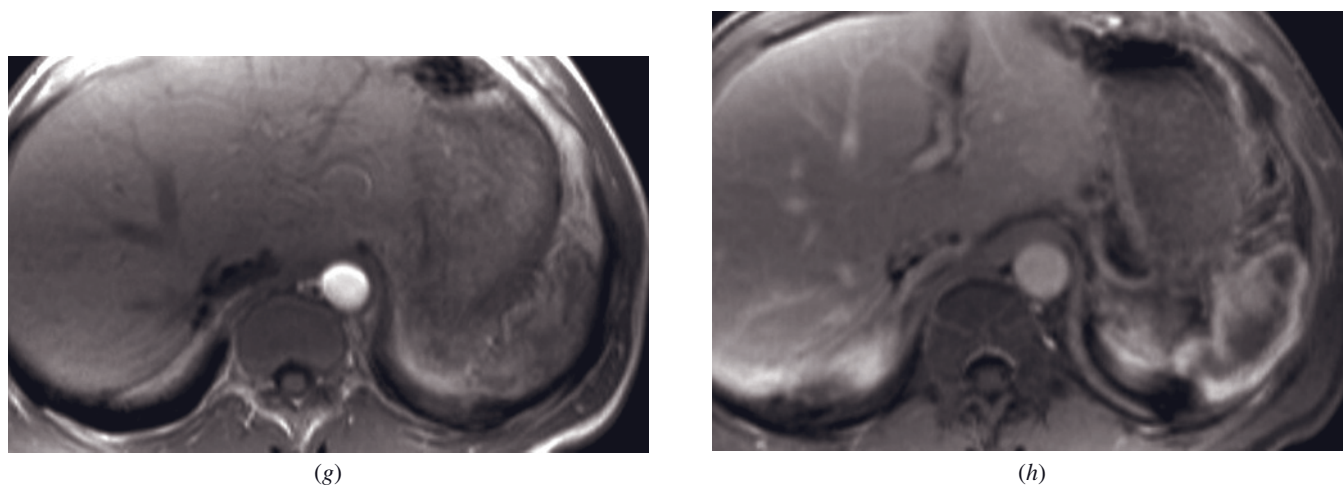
(Continued) SGE (g), and 90-s T1-weighted fat-suppressed SGE (h) images in a third patient demonstrate similar findings.
